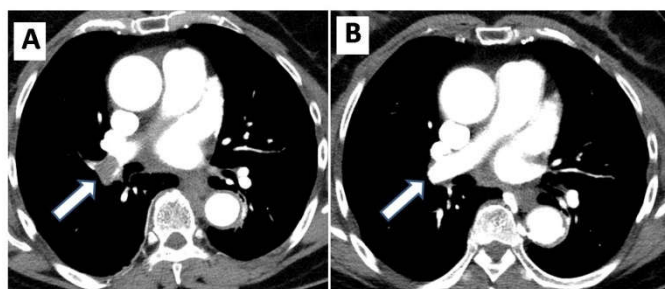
Thoracic CT images showing the acute pulmonary embolism in the right main pulmonary artery (arrow in A) and dissolution of blood clot at end of the treatment (arrow in B).
